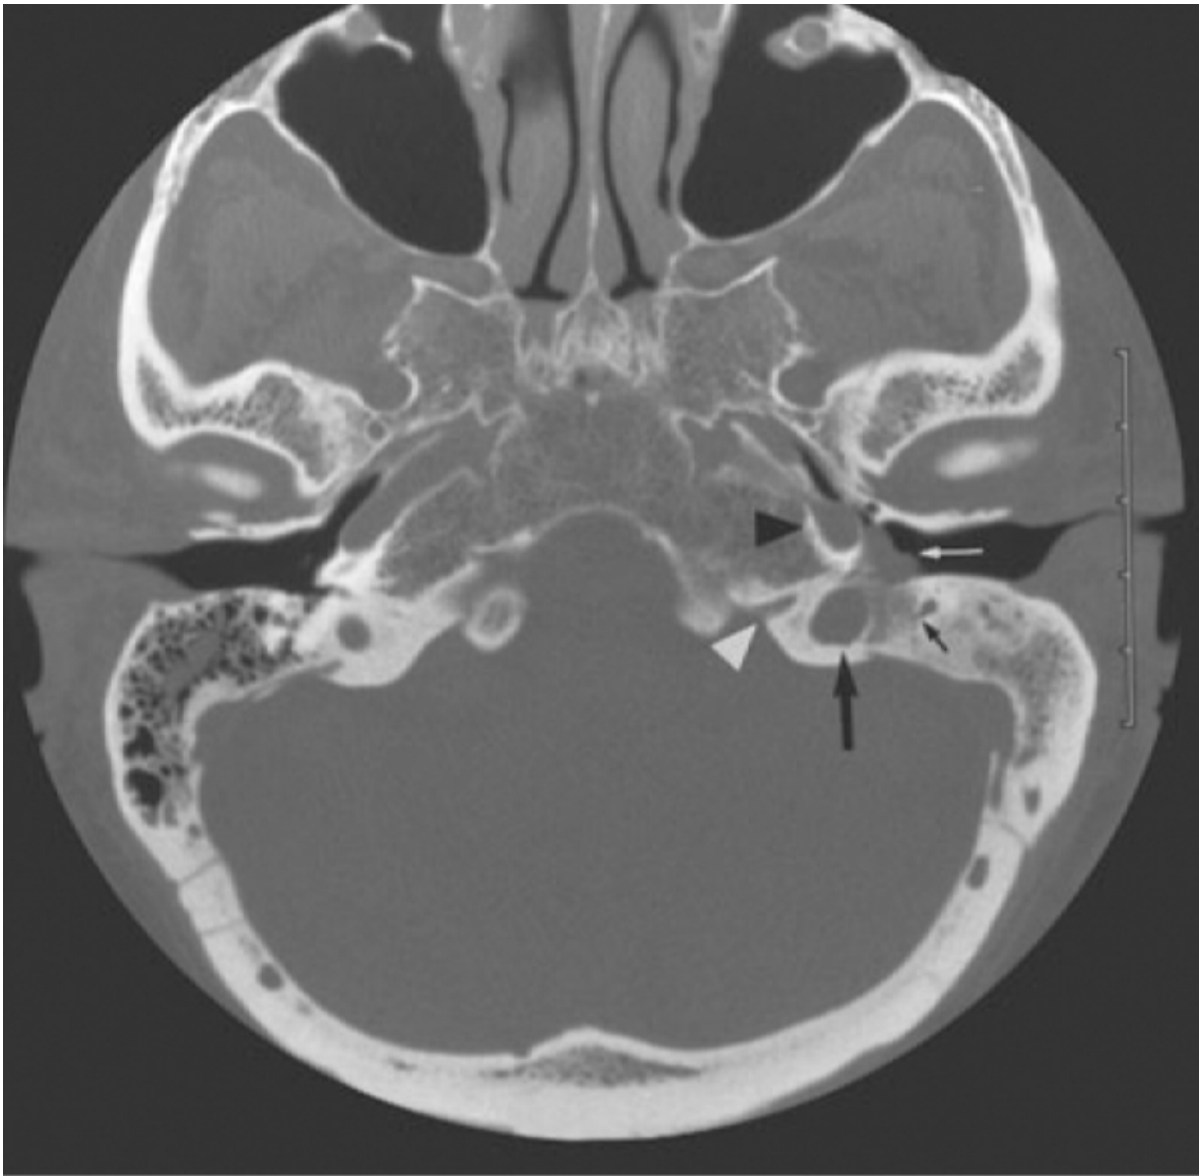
Bone-windowed computed tomography (CT) scan demonstrating the left middle ear and a hypotympanic mass (*white arrow*) infiltrating and eroding bone between the carotid artery (*black arrowhead*), the jugular vein (*large black arrow*), and the medial aspect of the facial nerve (*small black arrow*). The pars nervosa is not affected (*white arrowhead*).
